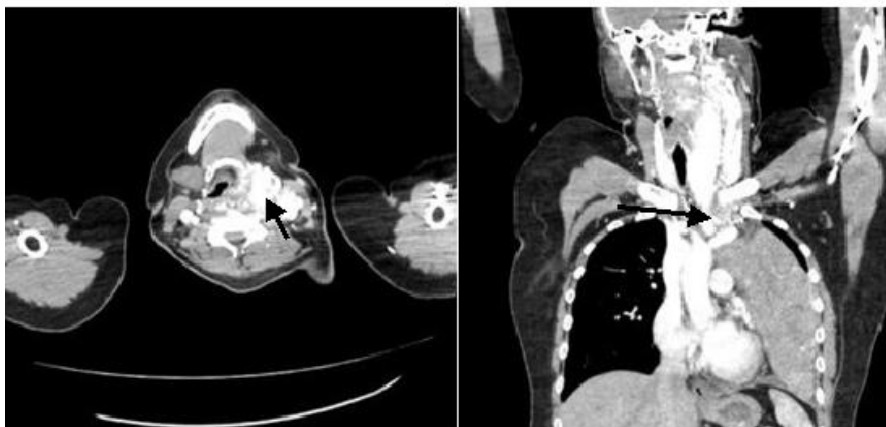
CTA showed left thyroid arteriovenous malformation with extrathyroidal nidus along the left carotid extending to the superior mediastinum. Massive thymic mass is visualized.
